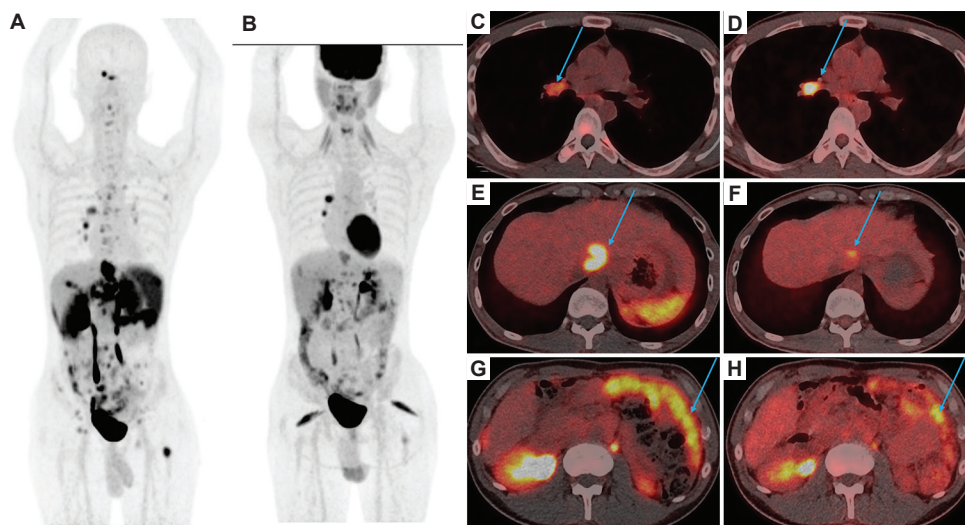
Positron emission tomography/computed tomography (PET/CT) imaging of a 33-year-old male with metastatic pancreatic cancer demonstrates heterogeneous lesions on the PET/CT scan. (A and B) maximum intensity projection (MIP) images of ^{68}Ga -DOTATOC-PET (A) and ^{18}F -FDG-PET (B) display multiple lung, liver, bone, lymph node, and peritoneal metastases. (C and D) Fused PET/CT of ^{68}Ga -DOTATOC (C) and ^{18}F -FDG PET (D) display higher uptake of ^{18}F -FDG in the right hilar node. (E–H) Fused ^{68}Ga -DOTATOC images of the abdomen (E and G) display higher uptake in liver and peritoneal metastases compared to the ^{18}F -FDG images (F and H). Blue arrows indicate metastatic lesions in the right hilar node, liver and peritoneum.
